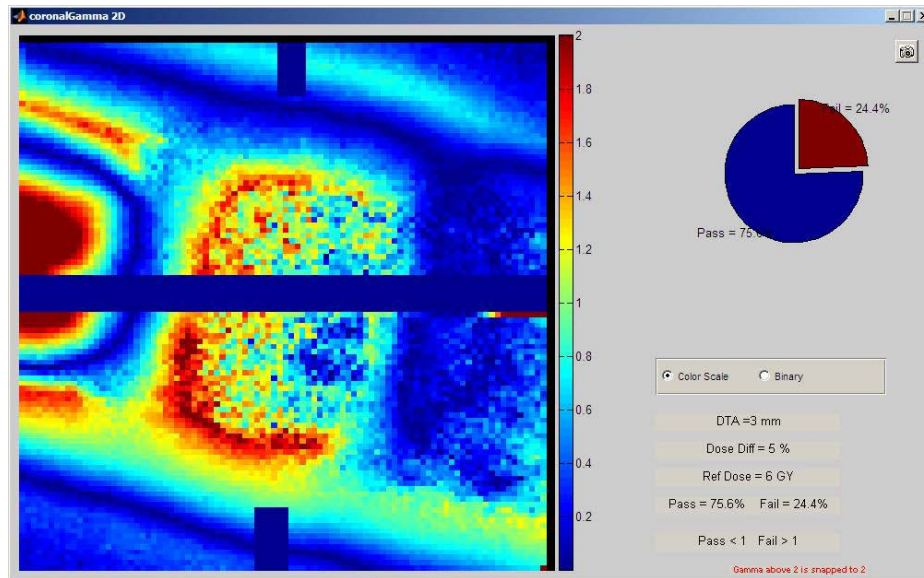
Plan 1b Trial 2 Coronal Gamma Analysis with PVC Shell contoured and CT Number set to match Eclipse Calibration Curve
